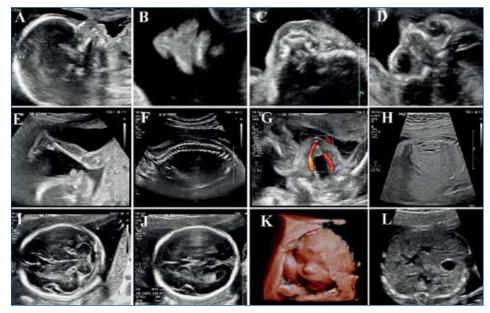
Normal fetal anatomy features. A: Facial profile. B: Fetal face - mouth, lips and nose evaluated in coronal view. C: Upper lip and hard palate alveolar ridge. D: Both fetal orbits appear symmetrical and intact. E: The fetal lower extremities. F: Longitudinal views of the spine and skin line. G: Bladder with surrounding umbilical arteries. H: Longitudinal view of the kidney. I: Cerebellar plane (cavum septum pellucidum, cerebellar hemispheres and vermis, cisterna magna, nuchal fold, cerebral peduncles, falx, thalami). J: Transventricular plane at the level of the atrium of the lateral ventricles (posterior horn of lateral ventricle, choroid plexus, cavum septum pellucidum). K: Fetal face features using 3-dimensional ultrasound volumes. L: Upper abdomen axial plane with stomach, portal confluent of the umbilical vein and aorta
